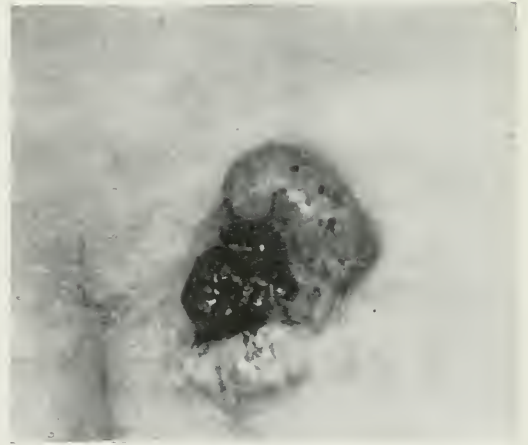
INOPERABLE CARCINOMA OF THE BREAST. DESTROYED BY ELECTRO-COAGULATION, FOLLOWED BY DEEP ROENTGENOTHERAPY, AND ALLOWED TO HEAL BY GRANULATION.
